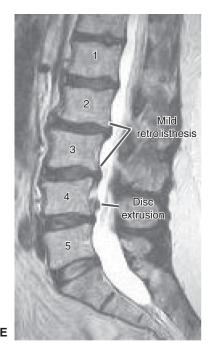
Disc breakdown, showing (A) breakdown and compression of fibrous layers of the annulus and displacement of disc material; (B) radial fissures/tears with nuclear material bulging against the outer annulus; (C) extrusion of nuclear material through the outer annulus but still in contact with the disc; (D) sequestration of nuclear material beyond the annulus; and (E) magnetic resonance imaging (MRI) scan of a 61-year-old patient with low back pain and symptoms radiating into the leg. The scan demonstrates moderate multilevel degenerative disc disease of T12–L1 through L4–5 with mild retrolisthesis of L2 on L3 and L3 on L4. At the L4–5 level, note a small diffuse disc bulge with large paracentral disc extrusion dissecting cranially.
